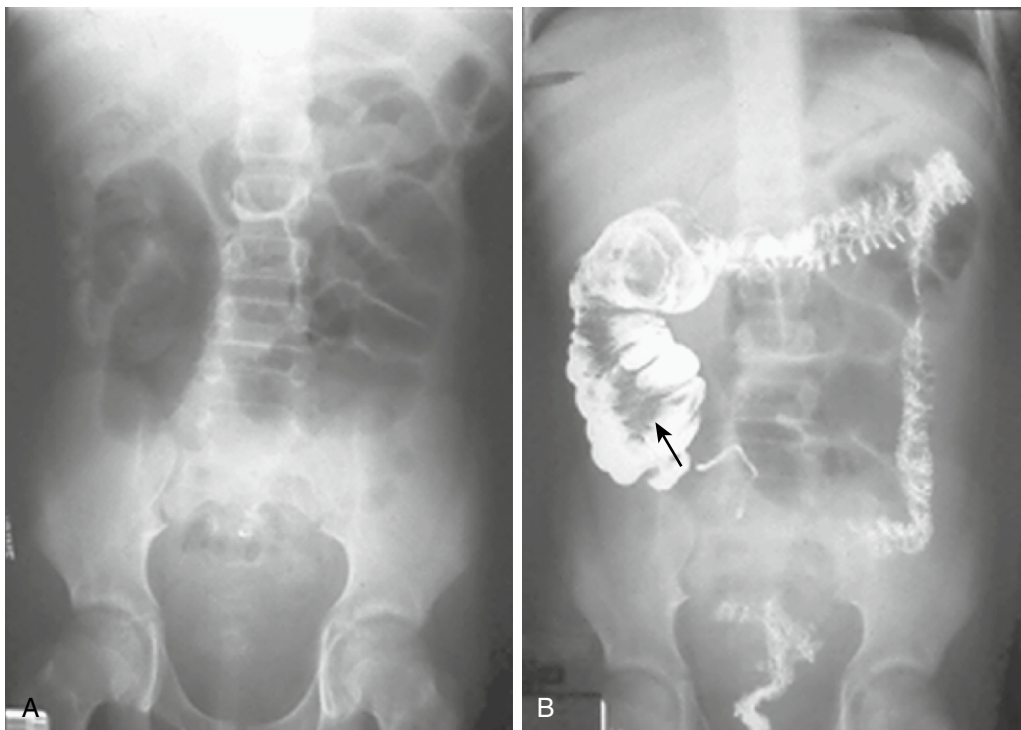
This 9-year-old presented with abdominal pain. A, The abdominal radiograph shows evidence of a possible small bowel obstruction. Because of the marked leukocytosis and other laboratory parameters, an intussusception due to non-Hodgkin's lymphoma was suspected. B, This was confirmed with a retrograde contrast study showing the intussusception (note the filling defect in the contrast medium, arrow) in the right colon. This was not able to be reduced radiographically and required operative reduction and intestinal resection.
